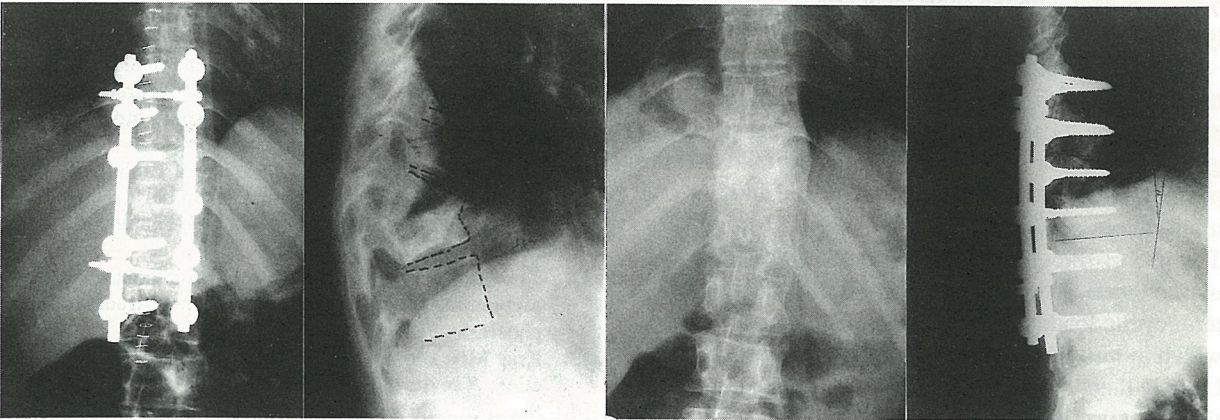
Preoperative and postoperative anteroposterior and lateral x-rays of a tuberculosis patient.
